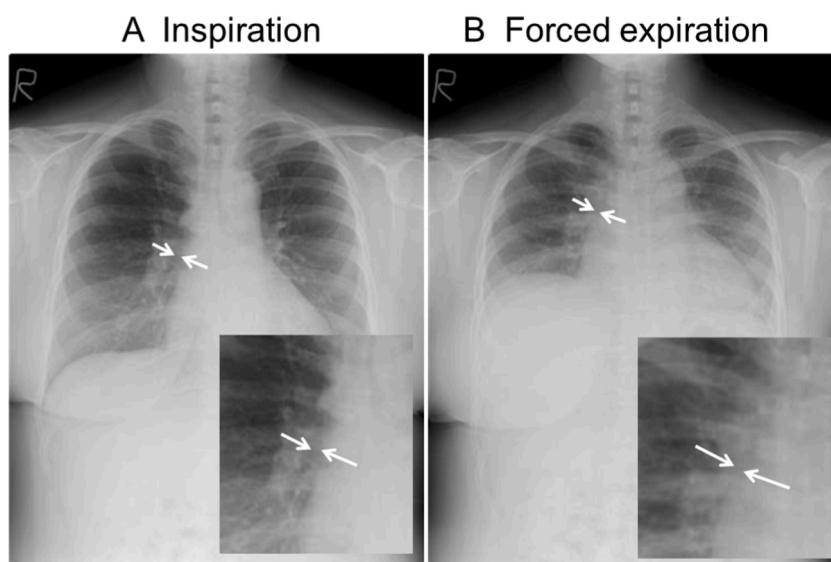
Chest X-ray at end-inspiratory (A) and forced expiratory phases (B). Narrowing of the bronchi is evident at the forced expiratory phase (arrows).
